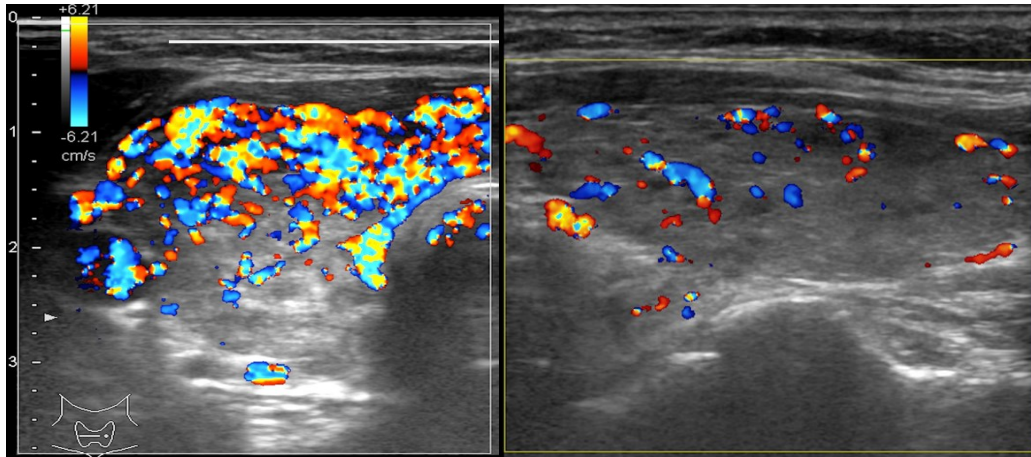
Color Doppler ultrasound of the thyroid in a case with Graves Disease and markedly increased vascular pattern (right) and slightly increased vascular pattern (left).
